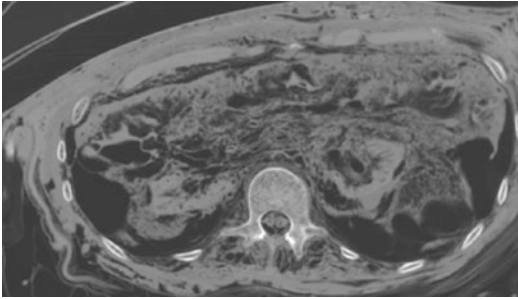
Axial CT scan shows maceration of the posterior skin of the body in a victim recovered some months after shipwreck, mainly visible on the right with adipocere at the torso; although with the advanced decomposition both are detectable
